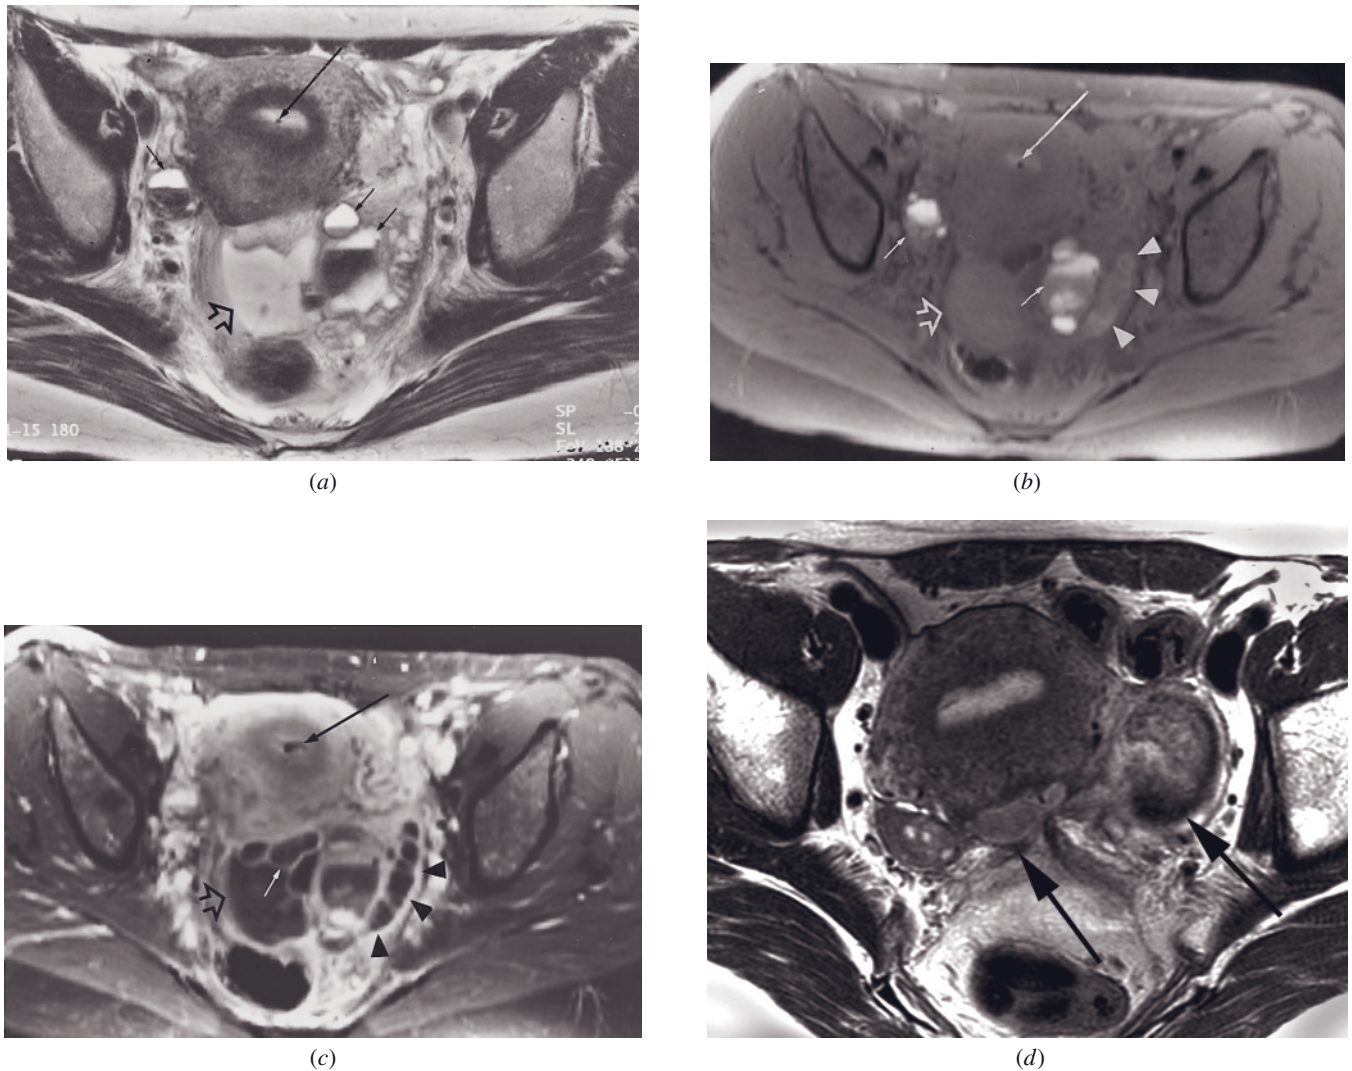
Endometriosis: T2 shortening with fluid-fluid levels. Transverse 512-resolution T2-weighted ETSE (a), T1-weighted fat-suppressed SE (b), and gadolinium-enhanced T1-weighted fat-suppressed SE (c) images in a 42-year-old woman with a 2-month history of pelvic pain, elevated CA-125, and complex adnexal masses on transvaginal sonography. Bilateral adnexal masses have high-signal-intensity components on T1-weighted images, which demonstrate fluid-fluid levels on T2-weighted images consistent with endometriomas (short solid arrows, a, b). Note the serpentine left hydro/hematosalpinx (arrowheads, b, c). Posterior to the uterus is a polygonal fluid collection (open arrow, a-c). After contrast, the septations of the masses (short solid arrow, c) enhance, as do the walls of the dilated left fallopian tube (arrowheads, c). The polygonal fluid collection has similar enhancement characteristics. Orthogonal views confirm the findings. Note the IUD within the endometrium (long solid arrows, a-c). At laparoscopy, bilateral endometriomas, endometriosis implants, left hydro/hematosalpinx, adhesions, and a peritoneal pseudocyst behind the uterus were found. MRI can add specificity to the finding of an elevated CA-125. Endometriosis at 3 T. Transverse T2-weighted ETSE (d), T1-weighted gradient-echo (e), and T1-weighted fat-suppressed gradient echo (f) images in a different patient show pelvic masses (arrows, d-f) with low signal on T2-weighted images and high-signal-intensity components on T1-weighted images that suppress with fat saturation. Also note evidence of adhesions, characteristic of severe endometriosis.
